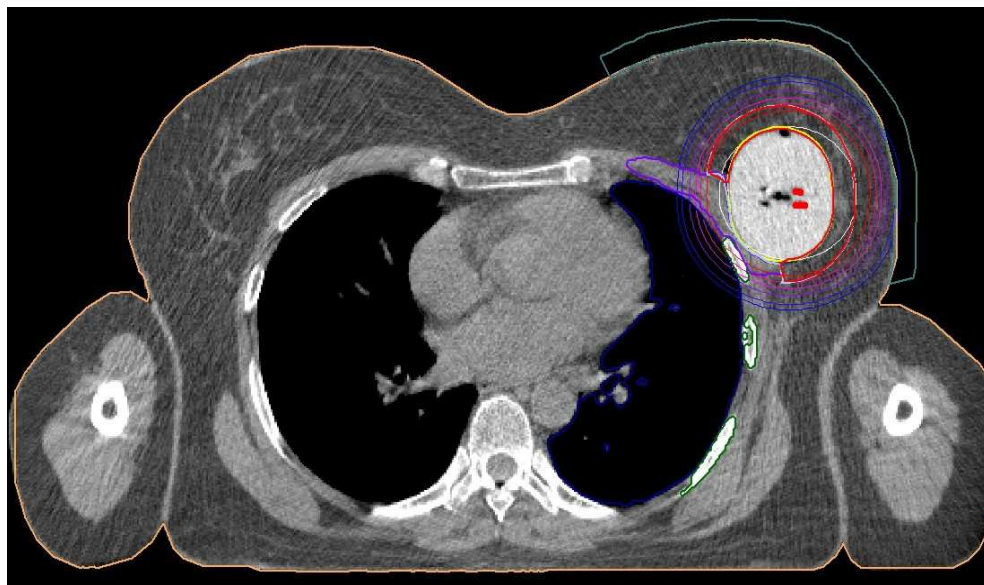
Breast cancer – Transverse CT scan of Contura® application. Final treatment plan. CT makes possible visualisation of all 5 catheteres within Contura balloon, assessment of isodoses in CTV, lung and skin (OARs).
